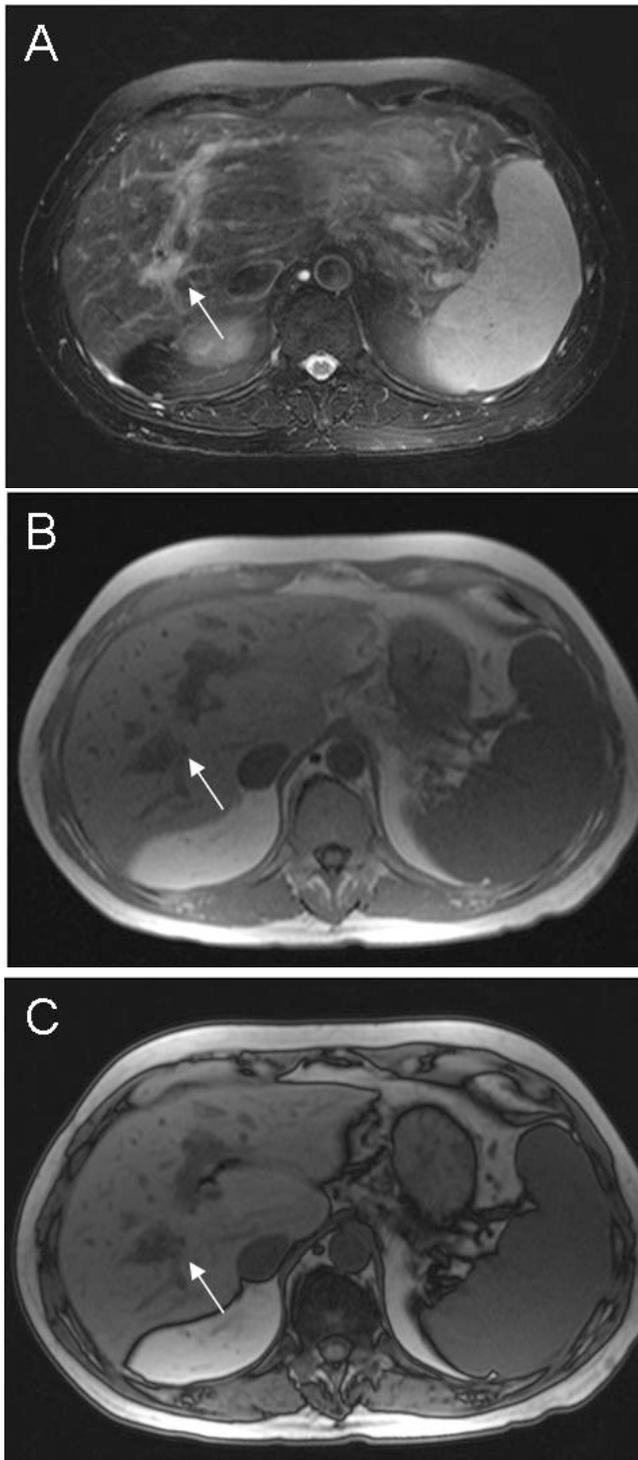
64-year-old male with iatrogenic arterioportal fistula. T2-weighted, fat-saturated image (A) demonstrates increased T2 signal (white arrow) within the posterior right lobe of the liver. This region demonstrates decreased signal on in-phase (B) and opposed-phase (C) imaging. No change in signal was noted between in- or opposed-phase imaging.
